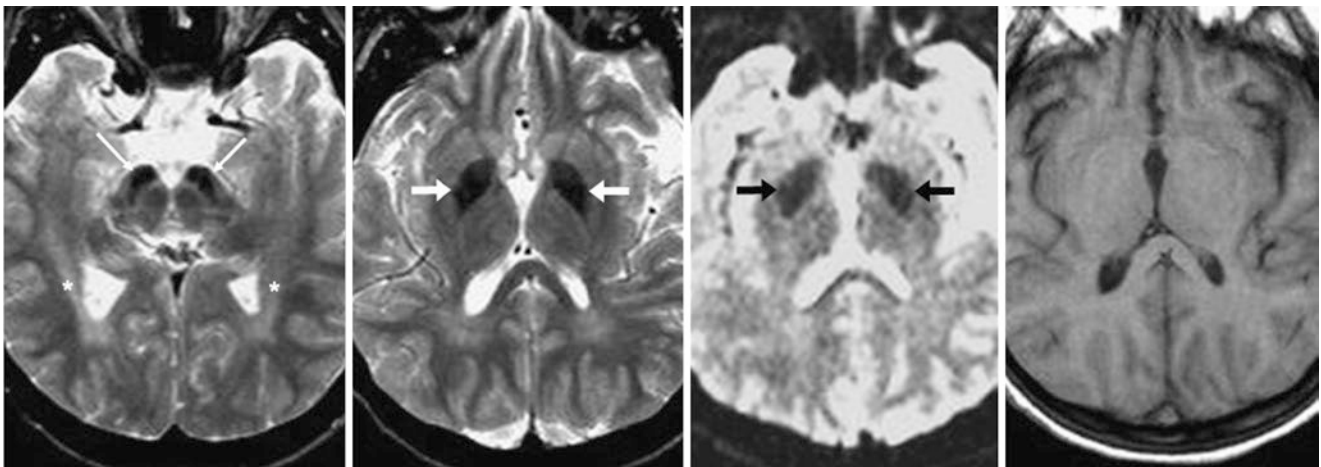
Comparison case of NBIA: pantothenate kinase associated neurodegeneration (PKAN). A 14 year old female underwent a 1.5T MRI that showed abnormally dark GP (arrows) and SN (thin arrows) on T2WI (left and left middle) and on the gradient echo b=0 map used to form a DWI (right middle), which is sensitive to susceptibility effects. T1WI (right) appeared normal. The findings were consistent with abnormally accelerated deposition of iron within those structures for the patient’s age. Also, note subtle abnormalities within the optic radiations (*)
